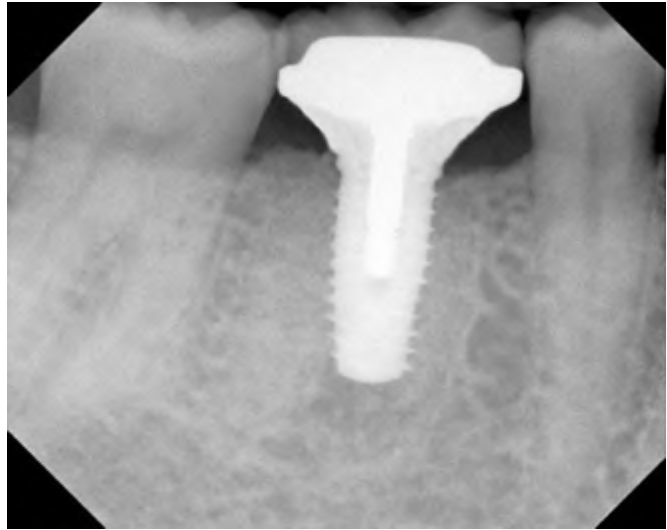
Radiograph with the implant-retained crown on the abutment demonstrated that the crown was seated properly onto the abutment. An ill-fitting crown would be identified by a radiolucent space between the crown and the abutment.
